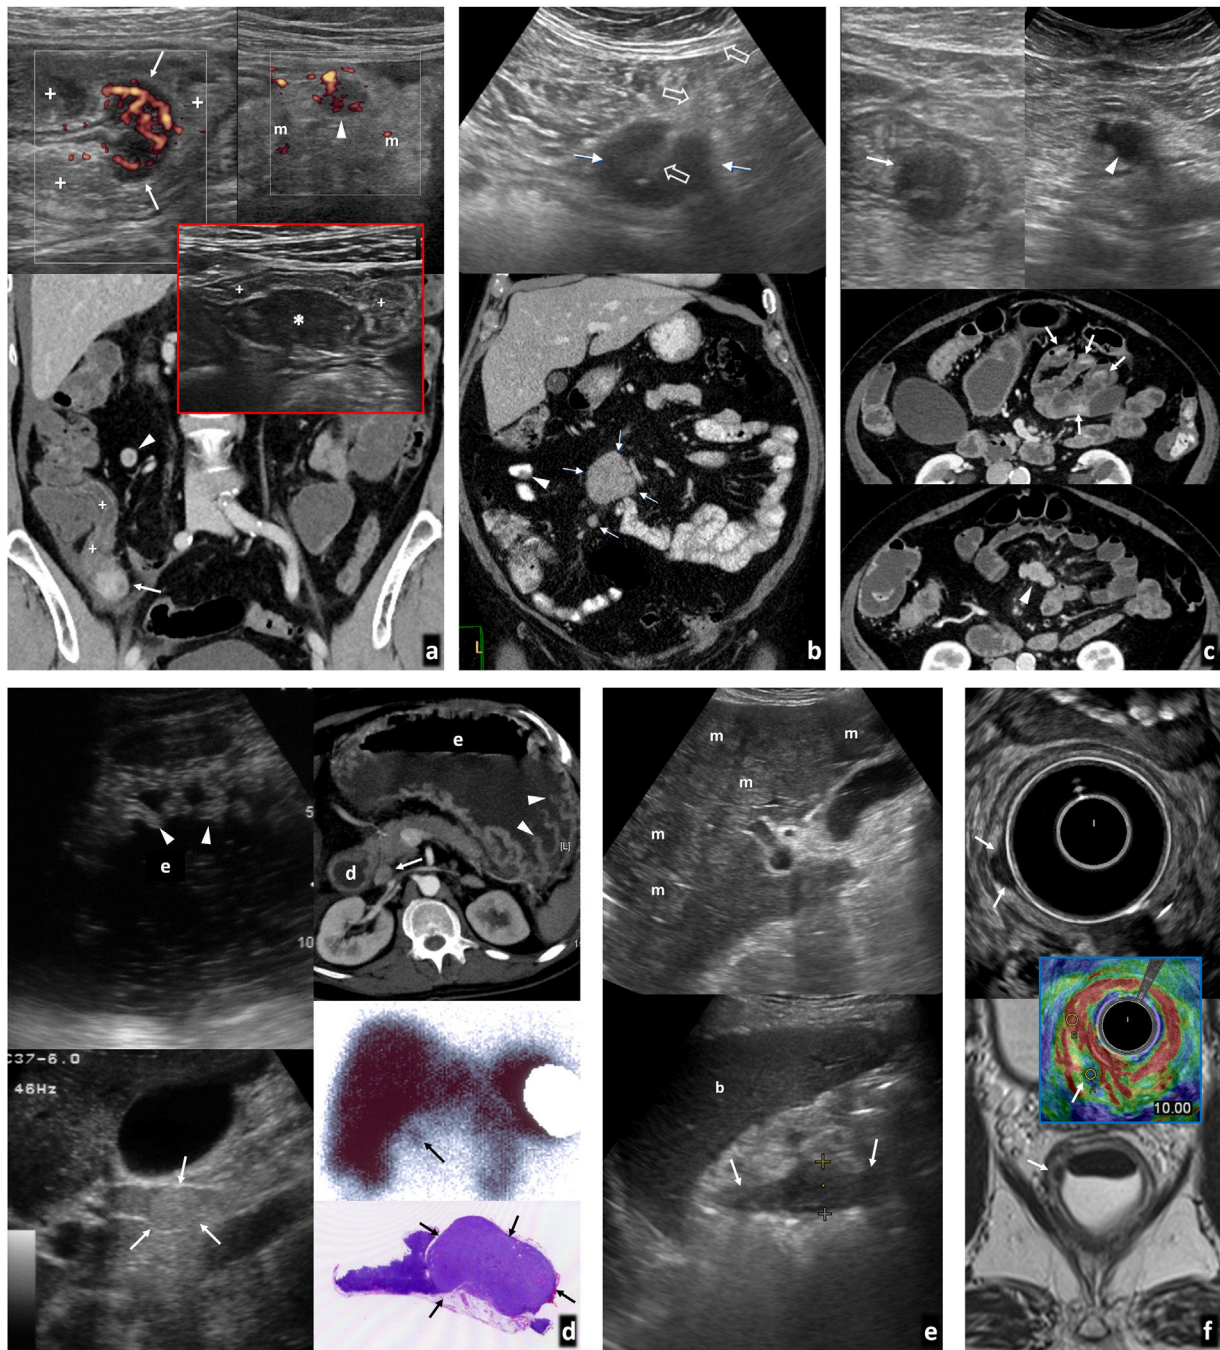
Neuroendocrine tumours. A) Terminal ileum carcinoid tumour. 62-year-old female with vomiting and abdominal pain. History of surgery for pituitary macroadenoma. Top image: ultrasound. Bottom image: coronal computed tomography (CT). Hypoechoic nodular lesion with abundant vascularisation on Doppler and CT (arrows), in the internal angle of the folded section of the distal ileum (+), with ineffective peristalsis in real time (video 2). Also, hypoechoic and vascularised lymphadenopathy (arrowheads) in swollen and echogenic regional mesocolon (m). Diagnosis made of multiple endocrine neoplasia-1 (MEN-1). Inset: endometrial implant (*) in the terminal ileum (+) in another patient, seen as a hypoechoic nodule infiltrating the serosa, retracting the loop, but not affecting the deep layers, showing similar findings, with which a differential diagnosis had to be made (not vascularised and without lymphadenopathy in this case). B) Ileal carcinoid only showing as a mesenteric mass. Top image: ultrasound-guided percutaneous biopsy (empty arrows) of a hypoechoic mesenteric nodule (arrow), which showed lymph node metastasis from a neuroendocrine tumour. Bottom image: coronal CT scan with oral and intravenous contrast. Mesenteric lymphadenopathy nodules (arrows). A primary intestinal millimetric carcinoid was identified during surgery and, retrospectively, could correspond to the small filling defect indicated by the arrowhead. C) Multiple jejunal carcinoids and mesenteric lymph node metastases. 71-year-old female with nonspecific abdominal discomfort. Top images: ultrasound scans. Middle and bottom: axial CT-enterography images in two different planes. Five hypoechoic, hypervascular tumours (one not shown) were detected in folded sections of the jejunum (arrows), with a small cluster of enlarged lymph nodes, also hypervascular and hypoechoic at the tributary mesenteric vein
